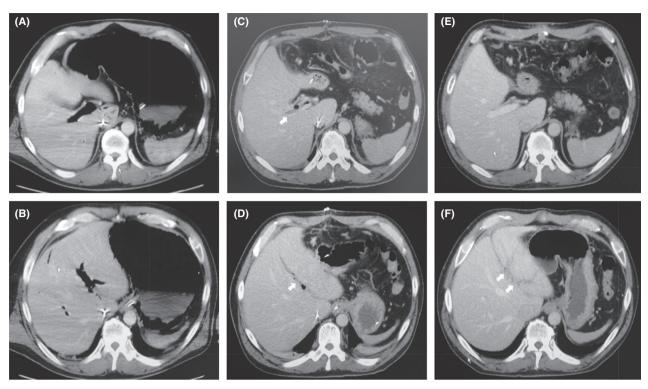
Changes in portal venous gas and portal vein thrombosis (PVT) on computed tomography (CT) with contrast (axial view) in a 51-year-old man with epigastric pain, vomiting, and diarrhea, A. B. Portal venous gas was seen in the right (A) and left (B) portal vein on abdominal CT at admission; however, PVT was not yet seen. C, D, On postoperative day 5, thrombosis was noted in the right portal vein (C) and the umbilical portion of the left portal vein (D) on abdominal CT (white arrow). A small amount of air still remained. E, F, On follow-up CT on postoperative day 39, thrombosis in the right portal vein had disappeared completely (E), but left PVT showed spreading (F) (white arrows).
